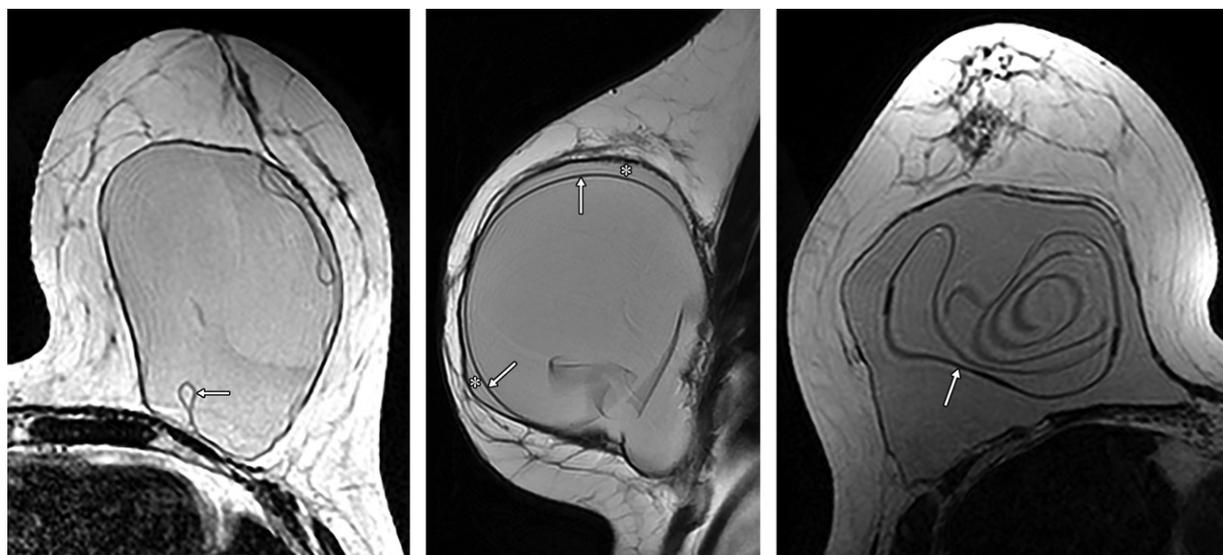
Signs of intracapsular rupture at MR imaging. (a) Axial T2-weighted MR image of the breast shows the keyhole or noose sign (arrow) with silicone expanding the apex of the radial fold. (b) Sagittal T2-weighted MR image depicts the subcapsular line sign as a hypointense line that parallels the implant contour (arrows). Extruded intracapsular silicone (*) displaces the implant shell inwardly. (c) Axial T2-weighted MR image of the right breast shows multiple hypointense curvilinear lines floating within the silicone gel, producing the linguine sign (arrow) and indicating complete collapse of the implant shell upon itself.
